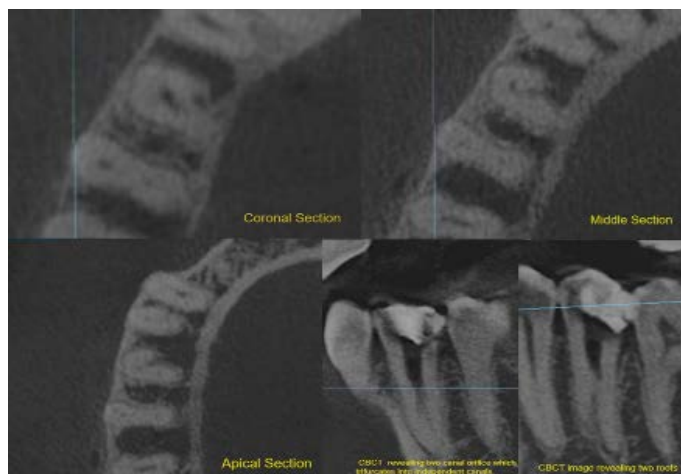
CBCT imagery of tooth #45 revealing three canals
